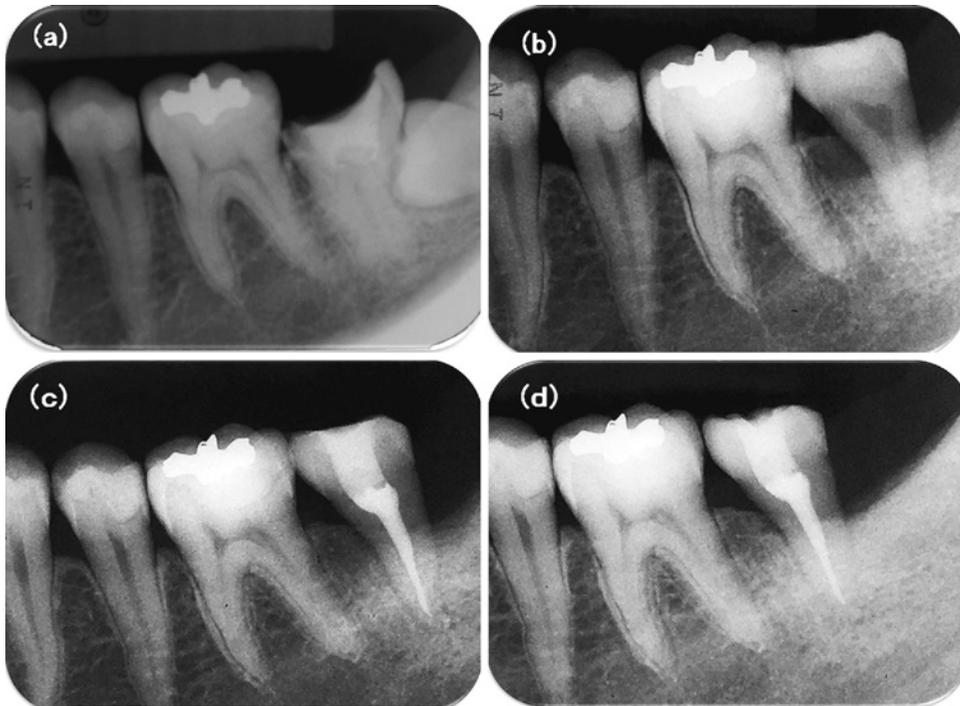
Preoperative and postoperative intraoral radiographs
